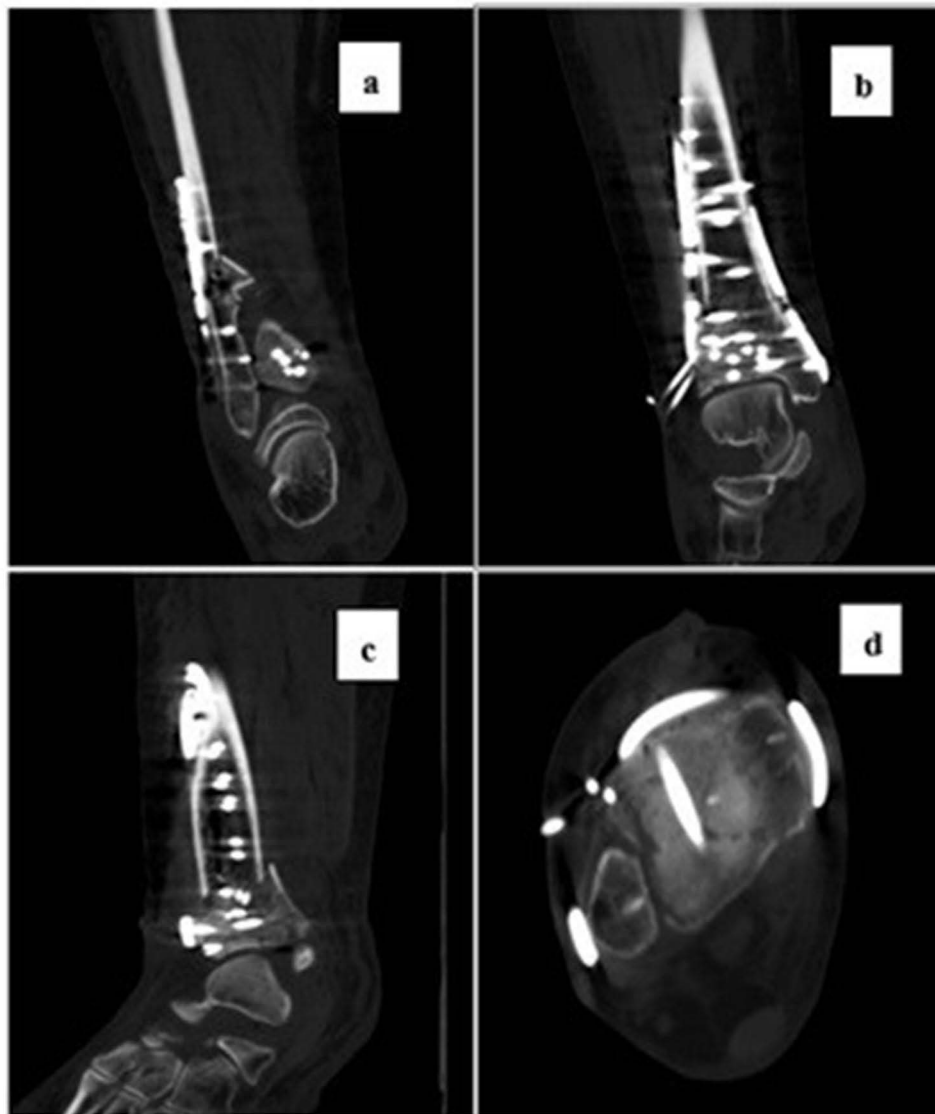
Postoperative CT imaging data. (a) The coronal CT view shows internal fixation of the fibular shaft. (b) The coronal CT view reveals internal fixation of the distal tibia, with good reduction of the articular surface. (c) The sagittal CT view demonstrates internal fixation of the distal tibia, and the articular surface is well - reduced. (d) The transverse CT section shows the distal tibial articular surface after internal fixation and reduction.
